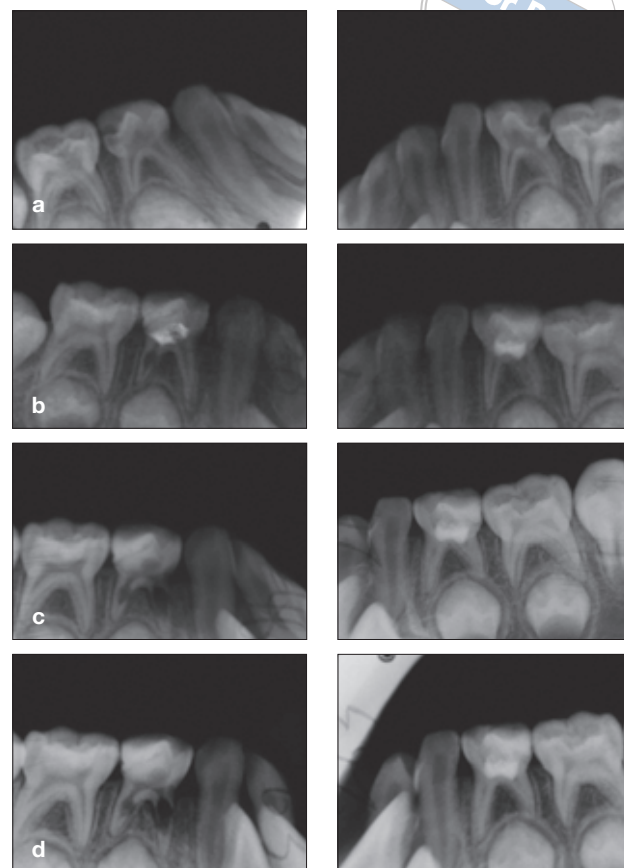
CH pulpotomy (left column) was performed on the right mandibular first molar and MTA pulpotomy (right column) on the left mandibular first molar. The MTA treatment showed success after 19 months, while the CH treatment failed. Radiographs taken: a) before operation; b) 5 months after pulpotomy; c) 15 months after pulpotomy; and d) 19 months after pulpotomy. At 5 months the CH-treated tooth showed internal root resorption while the MTA-treated tooth was normal. The internal root resorption in the CH-treated tooth enlarged with no periapical radiolucency, while the MTA-treated tooth remained normal.
